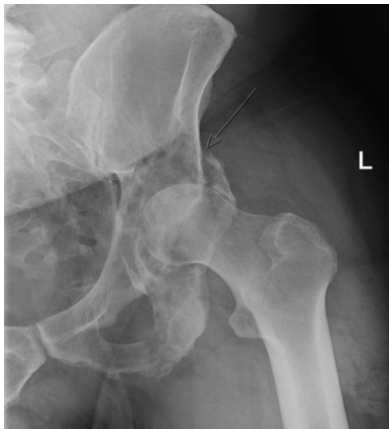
X-ray with comminuted, pathologic fracture of the superolateral left acetabulum. Non-displaced, comminuted fracture of the inferior pubic ramus.
